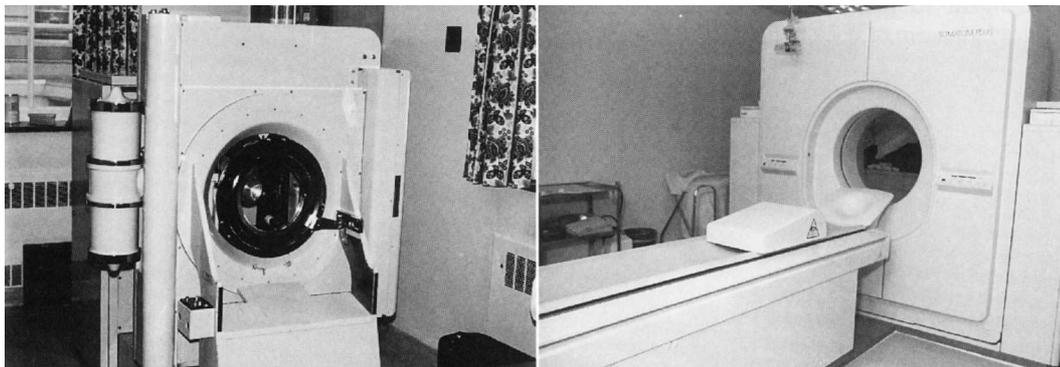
left*: First generation CT scanner, about 1976. *right*: Later-generation CT scanner (SOMATOM PLUS, SIEMENS MEDICAL SOLUTIONS), about 1994 [both images from ORRISON *et al.*, 1995]. More than their exterior, the quality of the images acquired using these machines changed dramatically (cf. Fig. 1.2).
